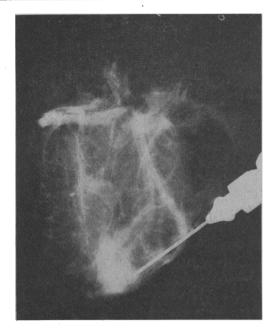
Shows x-ray of the left coronary tree which has been filled by injecting the left mammary artery 99 days after it was implanted into the left ventricular wall.
